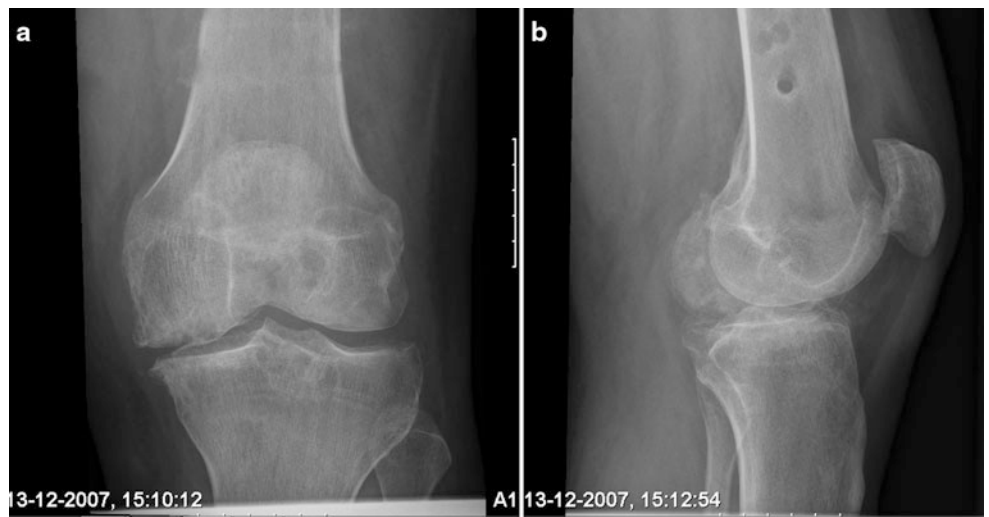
(a, b) Two years after distraction, weight bearing semi-flexed X-rays show still an increase in joint space width
